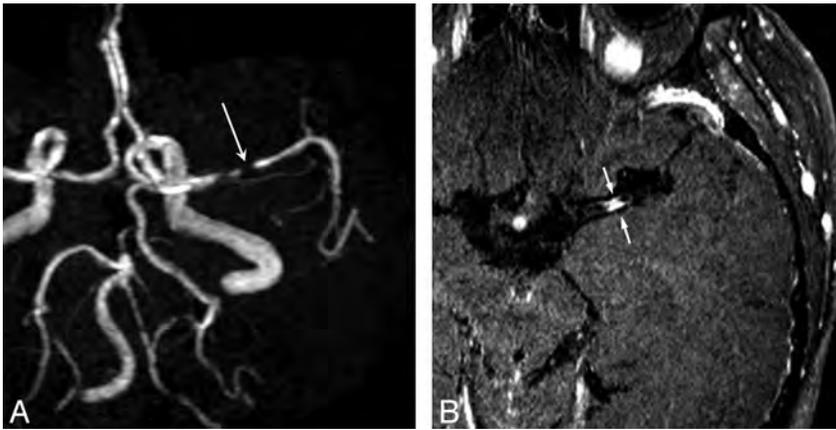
A 73-year-old man with severe MCA stenosis (A, long arrow) who presented with multifragmented infarctions at the ipsilateral MCA territory. Postcontrast MR image shows attenuated enhancement of the plaque (B, small arrows).
